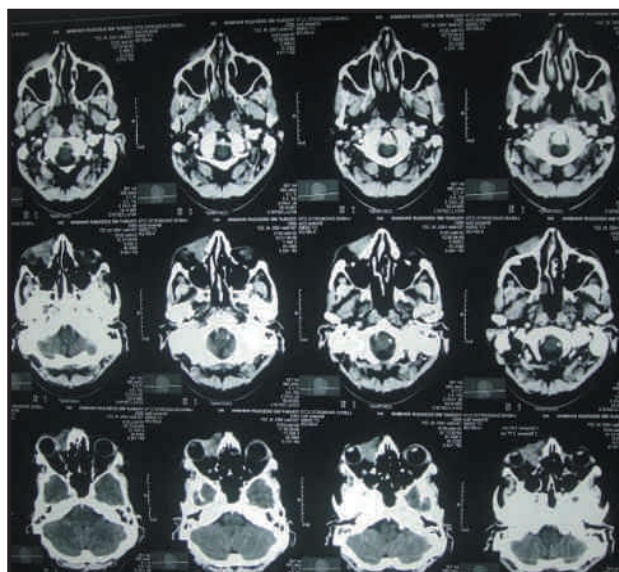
CT scan showing diffuse mass in lacrimal region
